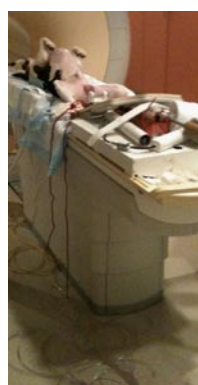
Canine positioning for magnetic resonance imaging-guided ultrasound therapy. Positioning of a canine in supine orientation on the patient table and preparation for the placement of the transurethral ultrasound transducer in the canine prostate.
